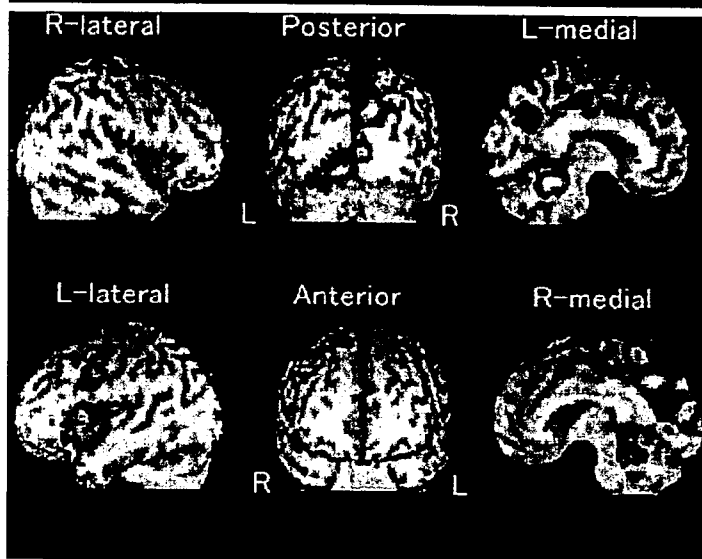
Easy Z-score imaging system (eZIS) image of single photon emission computed tomography (SPECT) before and after individual reminiscence therapy. Reduction of blood flow in the right frontal, and both left temporal, median-parietal and occipital lobes, posterior cingulated gyrus, and precuneus (upper panel). Comparing the SPECT findings before therapy, marked increase in the frontal lobe is noted (bottom panel).
